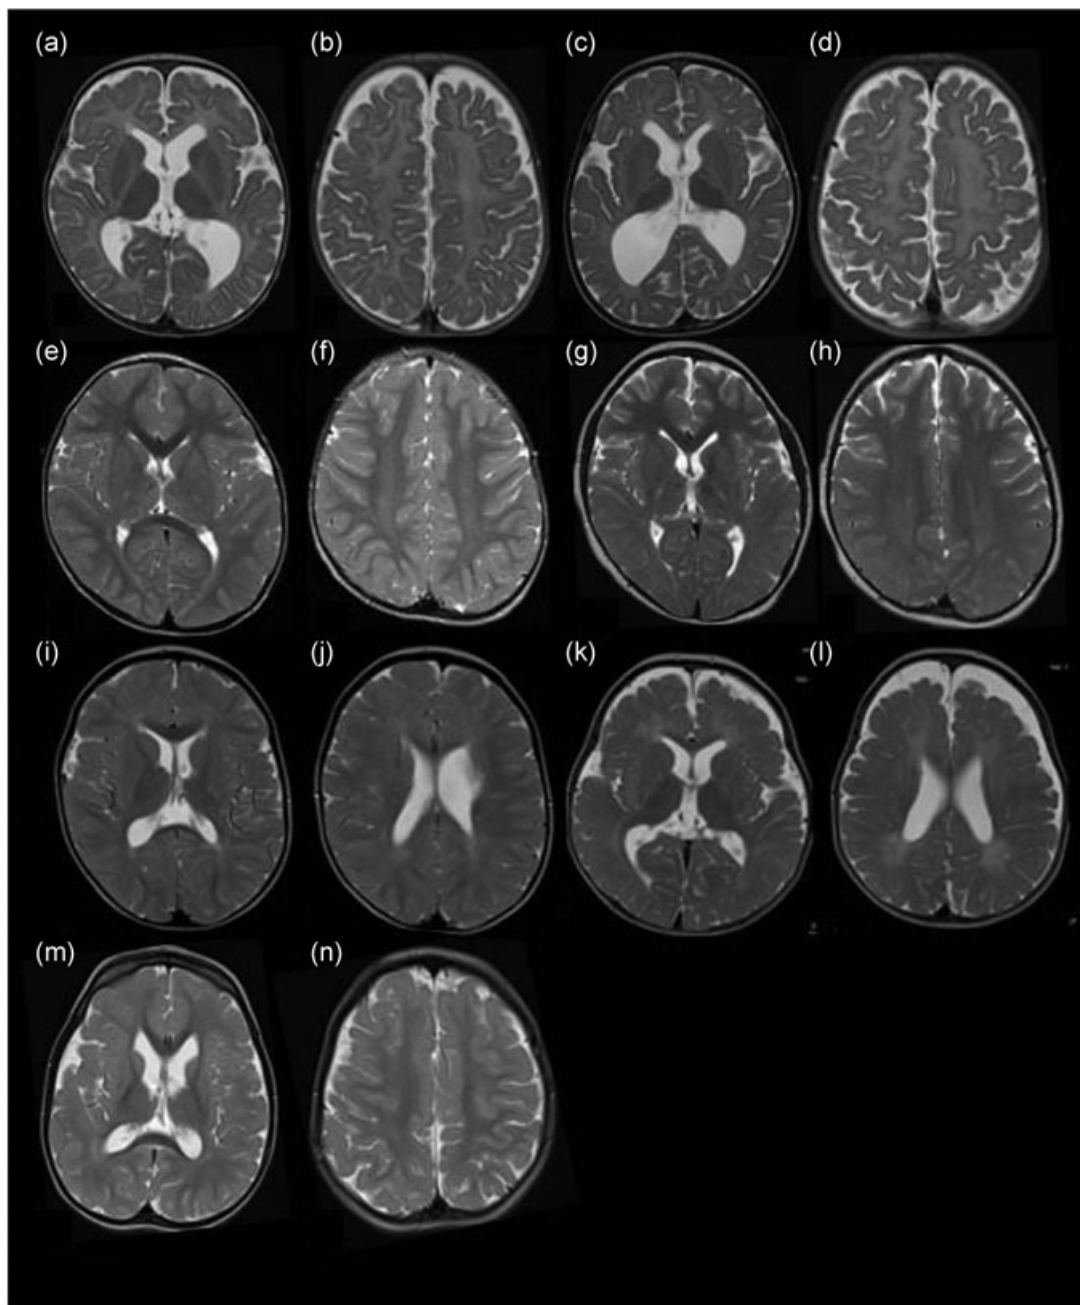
Evidence of CNS myelin defects in affected individuals carrying *FIG4* variants. MRI images. Axial T2 weighted MR images of patient 1 (Family 1) at 10 months (a,b) and 27 months (c,d) demonstrating the complete absence of myelination in cerebral white matter and internal capsule with no improvement on follow-up. Patient 2 (Family 2) at 30 months (e,f) and 8 years (g,h) demonstrates high signal in the posterior limb of the internal capsule and diffuse high signal in the posterior periventricular and deep cerebral white matter. Family 3, Sibling 1 at 25 months (i,j) demonstrates mild high signal in cerebral white matter with myelination present in deep and subcortical white matter. Family 3, Sibling 2 at 18 months (k,l) demonstrates more striking hypomyelination with very little normal myelin visible. The MRI of Patient 5 in Family 4 at 3 years of age was largely normal with nonspecific high signal in the periventricular and deep parietal white matter (m,n). CNS: central nervous system; MRI: magnetic resonance imaging
